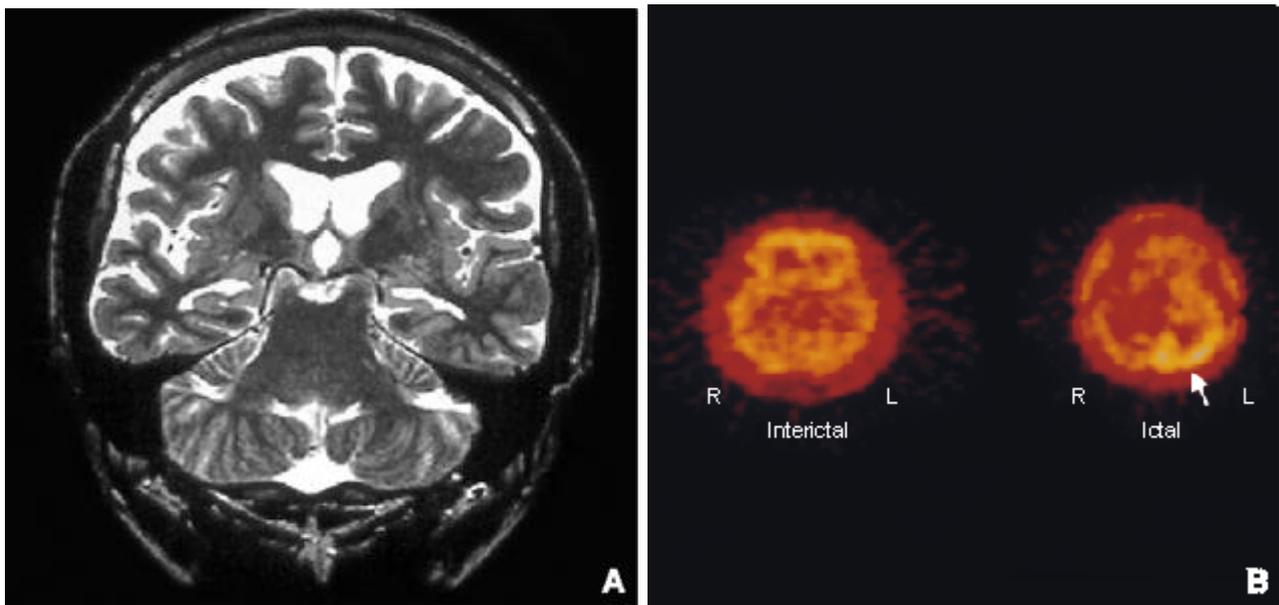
A patient who only had hippocampal sclerosis on MRI but with an epileptogenic zone in the left occipital area. A: Left hippocampal sclerosis on MRI. B: Focal hyperperfusion of the left occipital lobe on ictal SPECT (arrow). The patient had been free from seizure for one yr after the left occipital lobectomy.
